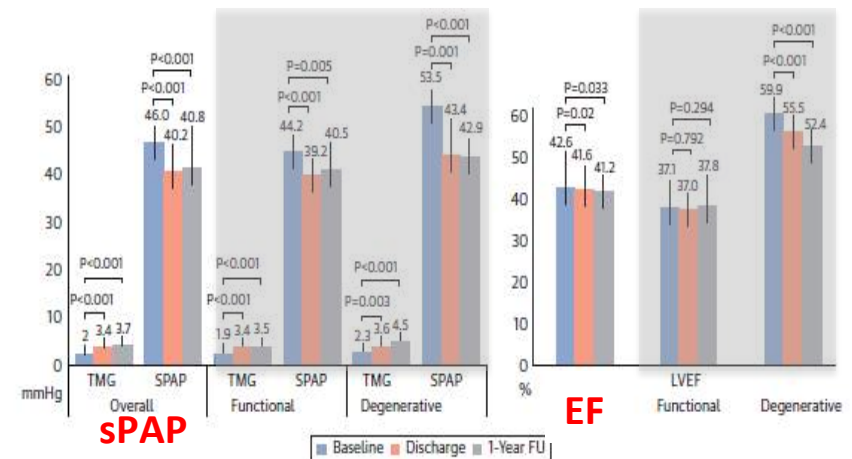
Echocardiographic Measurement of Transmittal Pressure Gradient, SPAP, and Ejection Fraction, at Baseline, Discharge, and 1-Year Follow-Up
